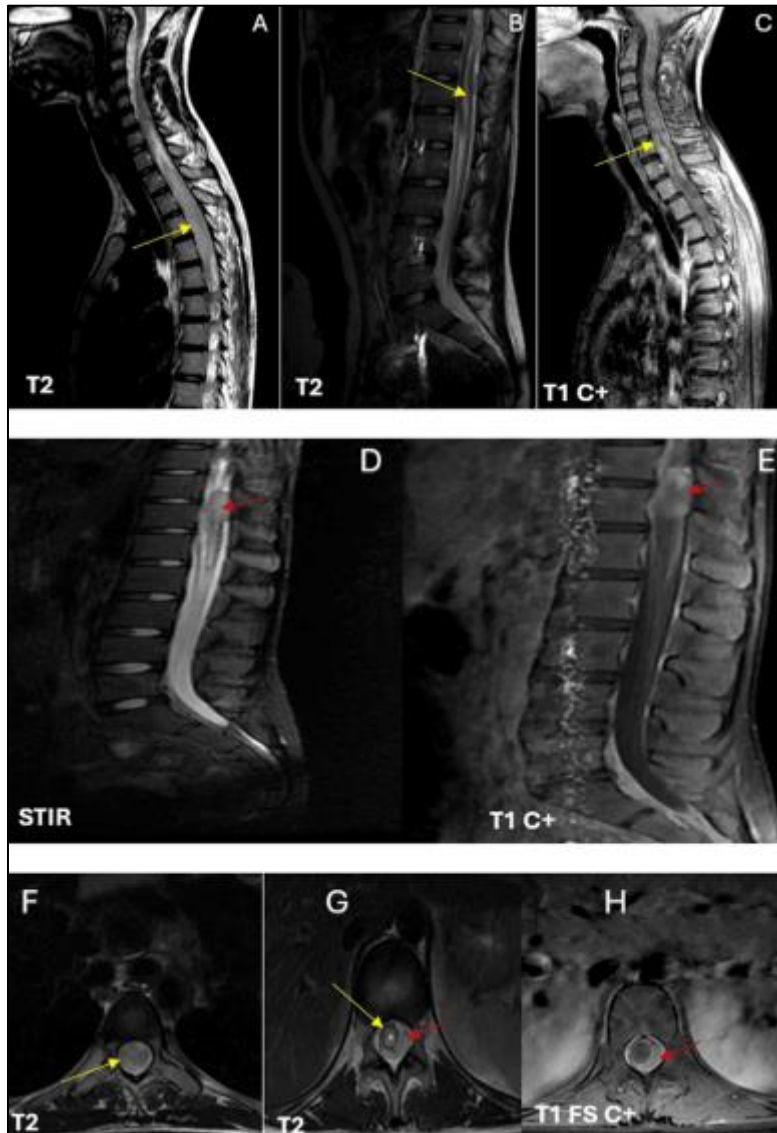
Initial cervico-dorso-lumbar MRI
